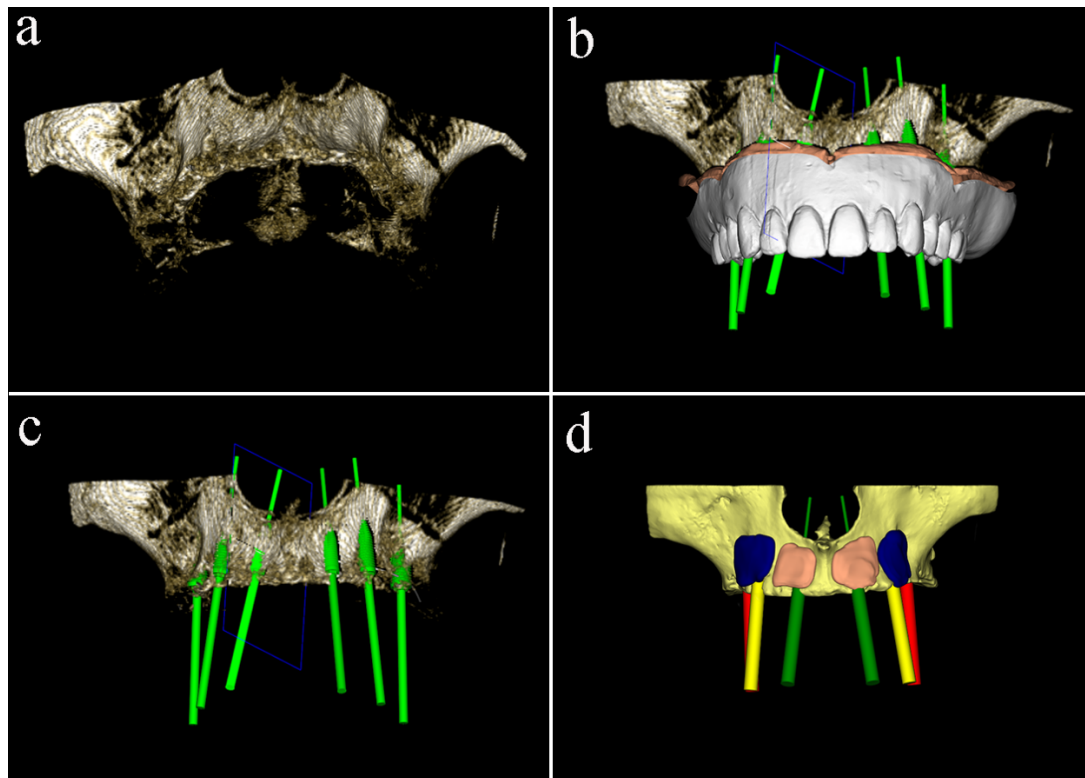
Diagnosis and treatment planning: (a) pre-operative cone-beam computed tomography (CBCT); (b) virtually planned prosthetic-driven position of the implants; (c) bone defects at planned implant sites; (d) virtual model of the graft blocks.
